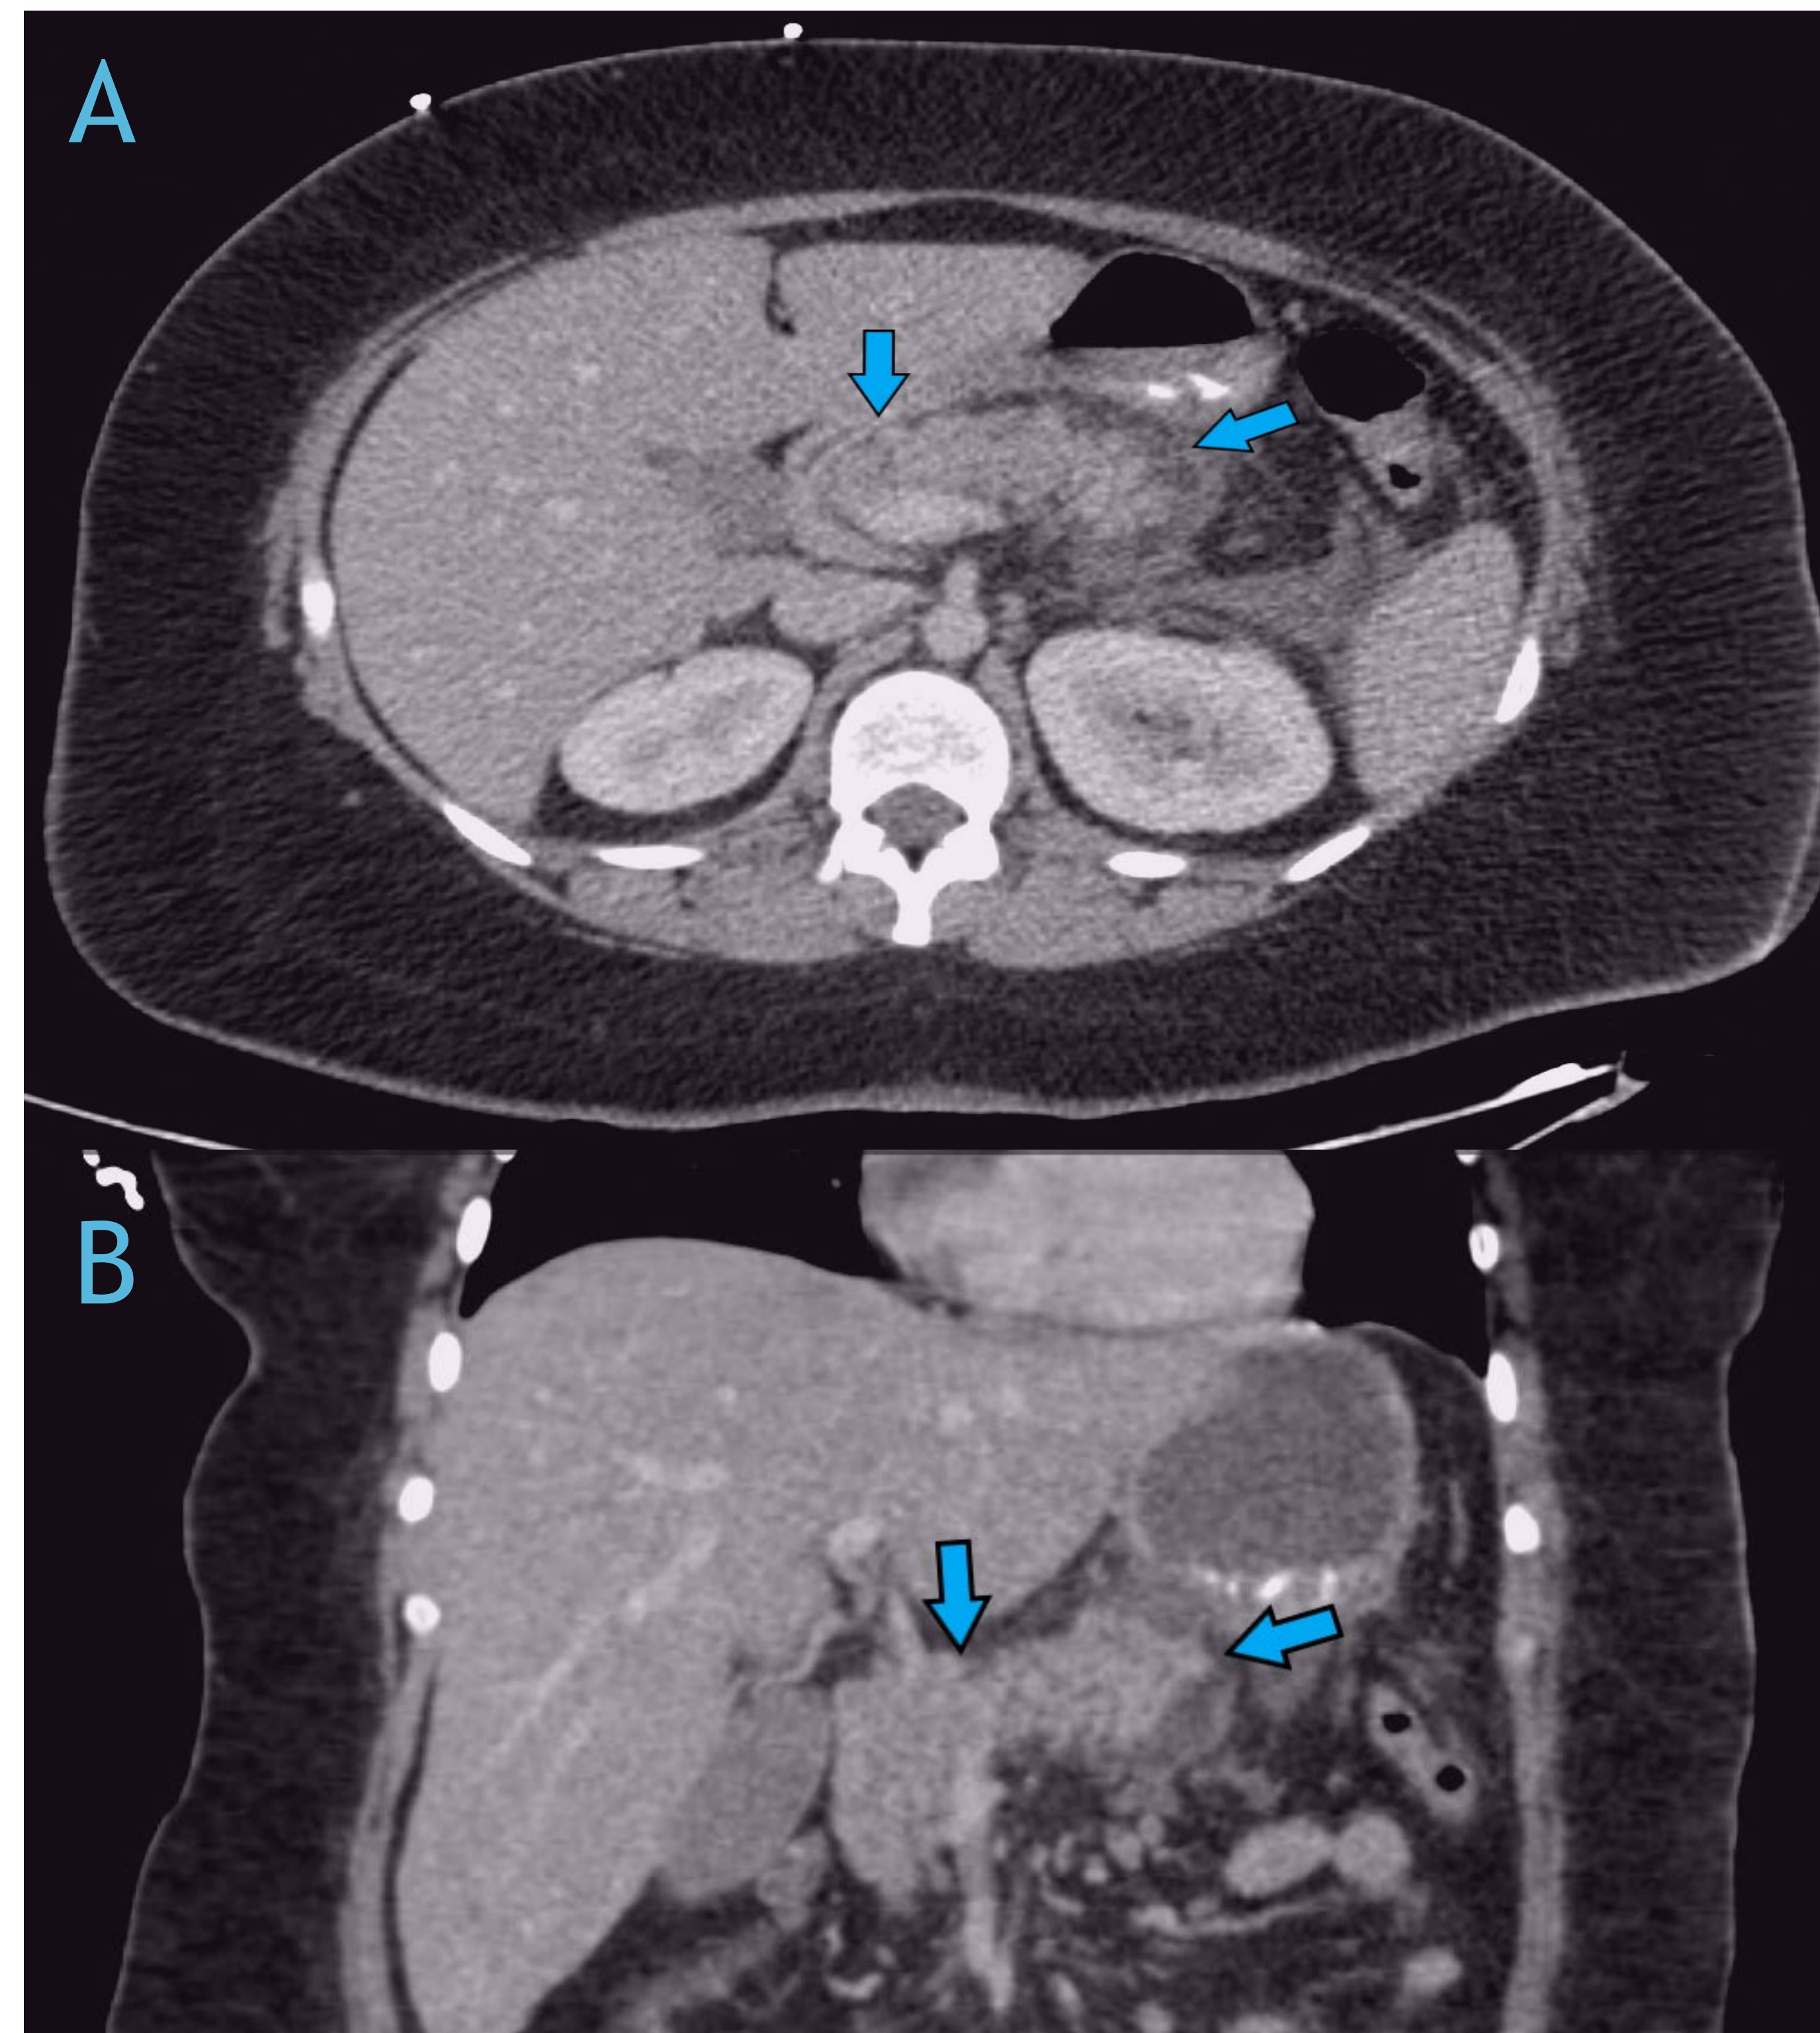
(A, B): Computed tomography images showing pancreatic inflammation and edema (arrows) surrounding the head and tail of the pancreas (C): The role of insulin deficiency in causing HTG leading to AP. Decreased inhibition hormone-sensitive lipase leads to increased FFA which will be converted to serum HTG causing AP. (3)
